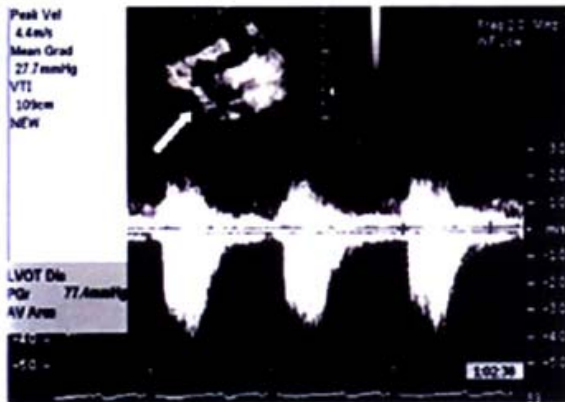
Suprasternal notch view during transthoracic echo showing coarctation of aorta flow gradient at the aortic isthmus (arrow).
